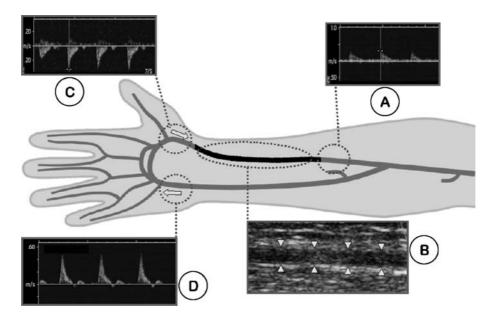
Doppler flow profiles in a patient with occluded radial artery after radial access.
